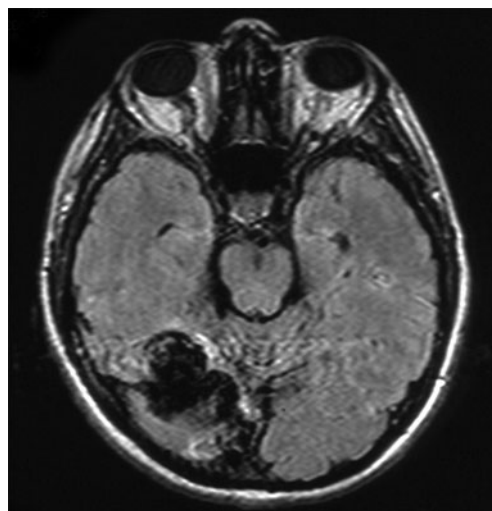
Axial brain magnetic resonance imaging fluid-attenuated inversion recovery sequence showing signs of flow void in right occipital area
